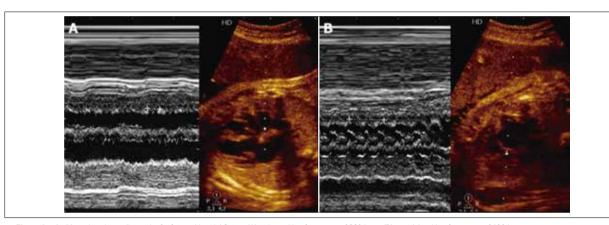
An M-mode echocardiograph of a fetus with atrial flutter: (A) atrium with a frequency of 360 bpm; (B) ventricle with a frequency of 180 bpm.
